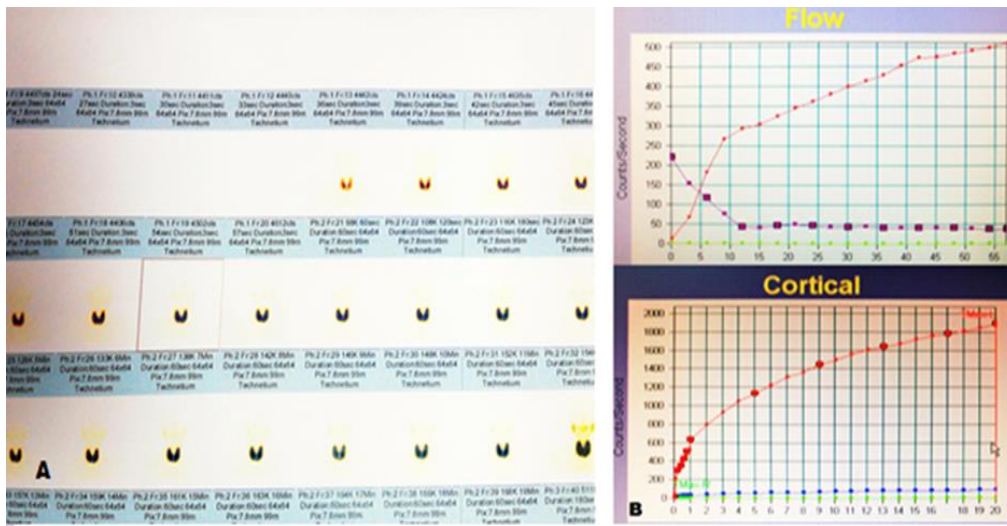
Dynamic scintigraphy of thyroid gland show blood perfusion and thyroid uptake of (99m) Tc pertechnetate (A) and graphic presentation (B) in one patient with hyperthyroidism
